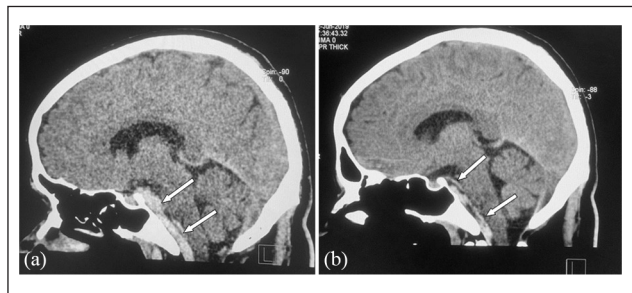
Sagittal CT scan of the head showing (a) retroclival hematoma and (b) resolving hematoma.
